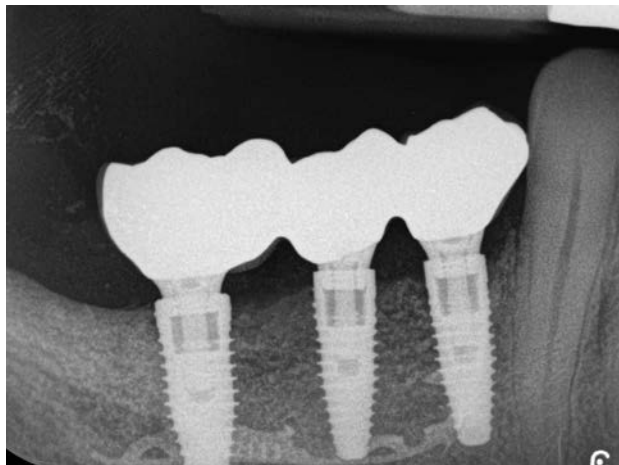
Peri-apical x-ray one year after definitive prosthesis fitting
